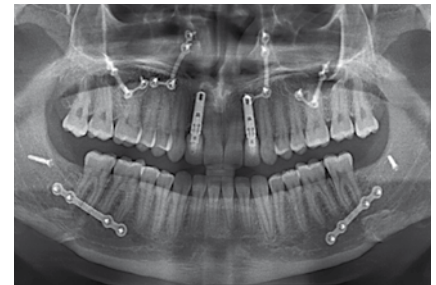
Final panoramic x-ray.
